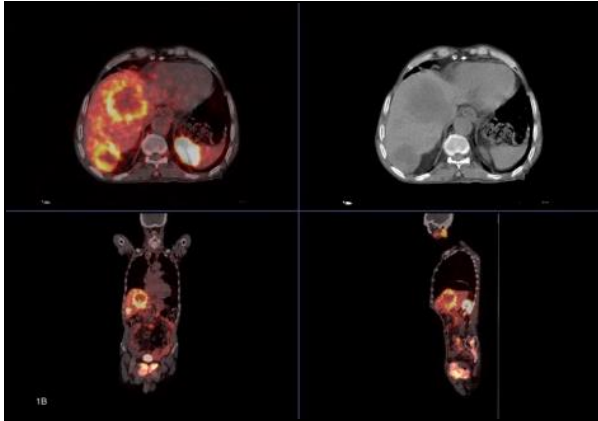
^{68}Ga -PSMA PET-CT findings related to ^{68}Ga -PSMA ligand uptake showing: mediastinal lymph node invasion, bone and liver metastases in a 62-year old prostate cancer patient with liver SUV max of 18.3, Gleason score of 10 and PSA level of 880 ng/ml.
